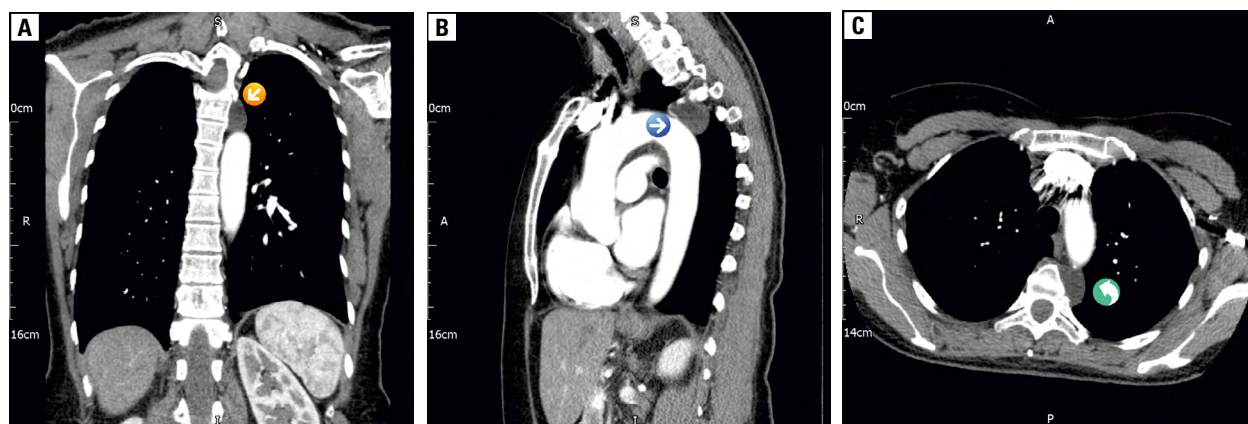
A. Chest computed tomography (CT) coronal view; soft tissue mass at the level of aortic arch (orange arrow); B. CT chest-sagittal view; soft tissue mass at the level of aortic arch (blue arrow); C. CT chest-axial view; soft tissue mass at the level of aortic arch (green arrow)
